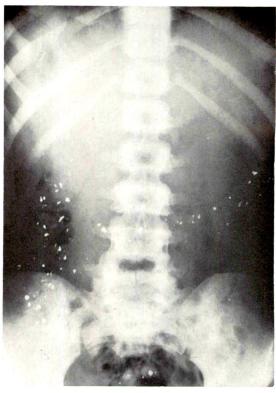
Roentgenogram of a 12 year old male showing opaque colonic opacities quite similar to those seen in Figure 1.
